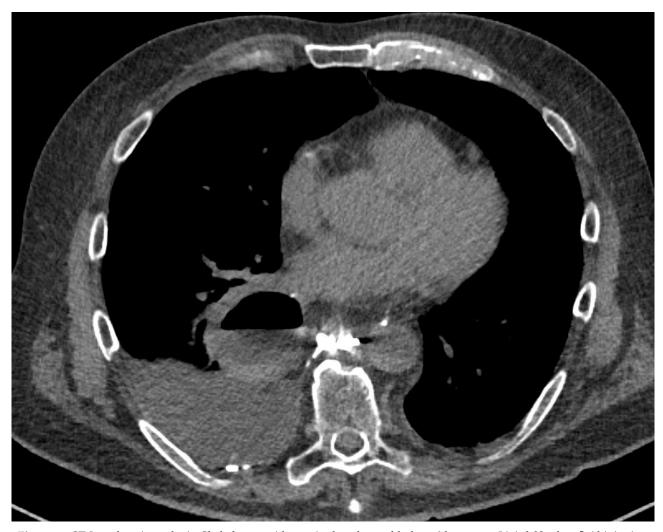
CT-Lymphangiography in Chylothorax, with massive lymph vessel leakage 6 hours past Lipiodol® ultra-fluid injection.
